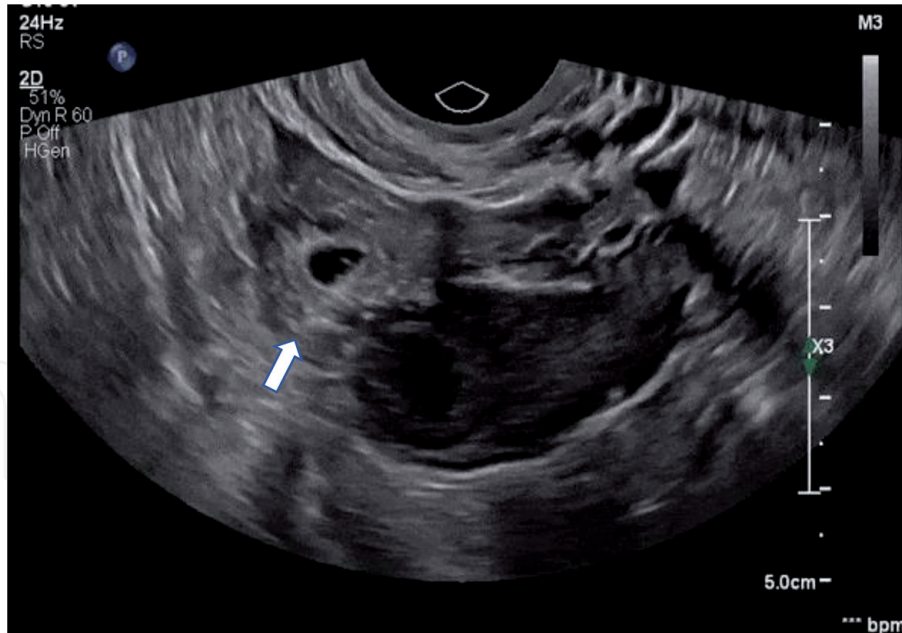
Ovarian ectopic pregnancy. Transvaginal ultrasound showing a gestational sac located within the ovarian stroma (white arrow) [12].
